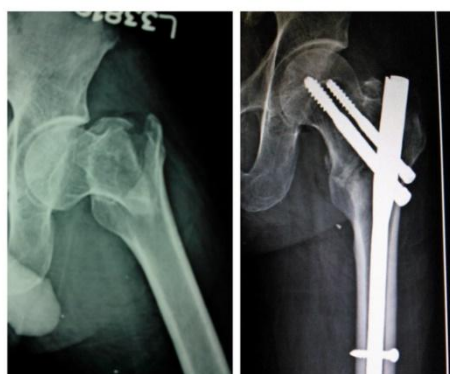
pre and post operative x-rays of a 69 year old male patient with intertrochanteric fracture femur managed with proximal femoral nailing
